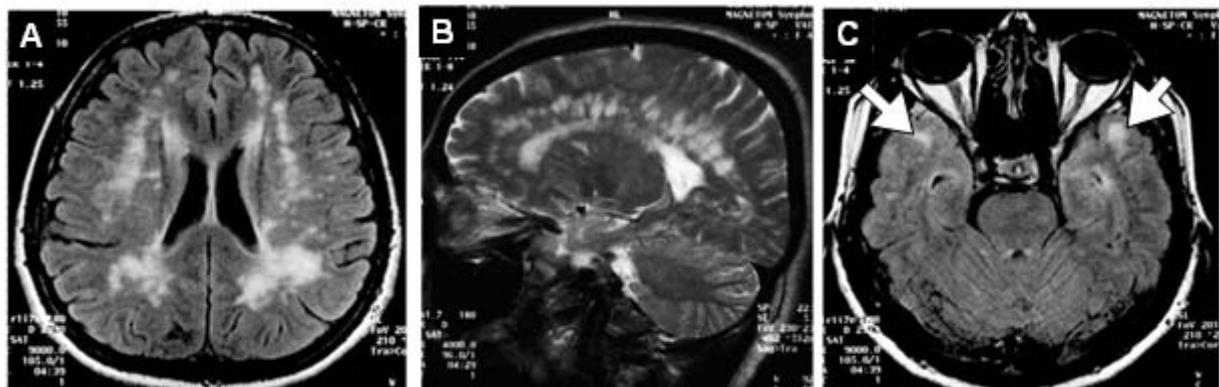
MRI of the brain with fluid-attenuated inversion-recovery (FLAIR) show high-signal intensity lesions (A) in the periventricular, subcortical white matter and (B) mimicking Dawson's fingers in the sagittal view reminiscent of multiple sclerosis. However, (C) high-signal intensity lesions in the temporal poles (arrows) are characteristic of CADASIL.
